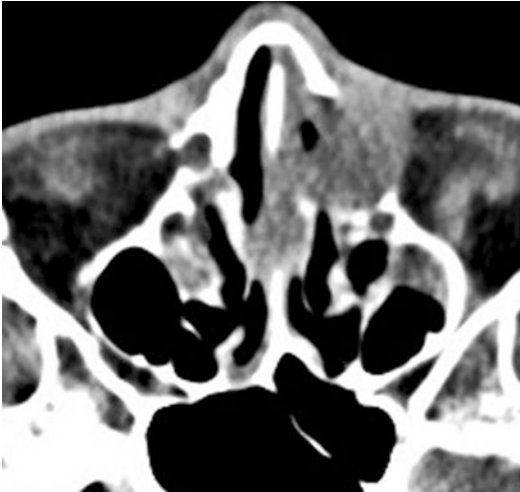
CT scan axial view showing tumor infiltration of left lacrimal sac fossa (inverted papilloma)
